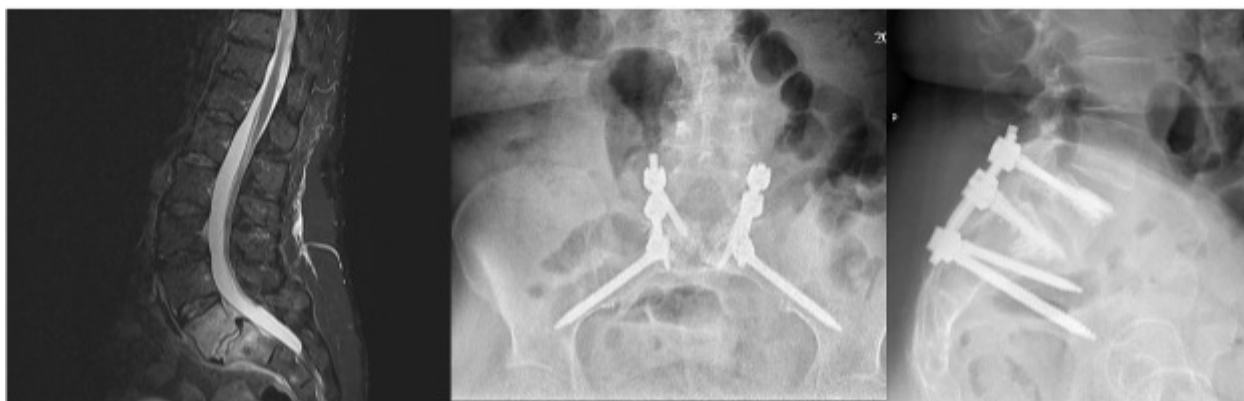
Sagittal T2 sequence MRI, and AP, and Lateral radiographs of Lumbar spine, demonstrating successful debridement and stabilization of lumbosacral osteodiscitis supplemented with ABC.
